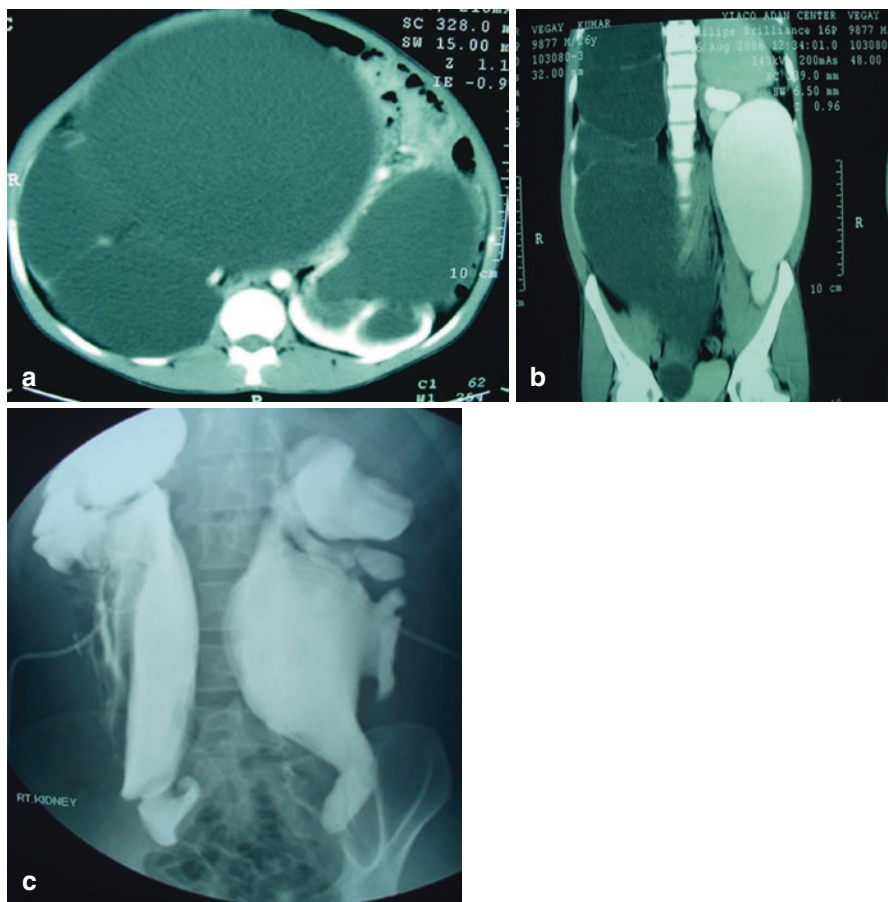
(a) CT with IV contrast showing bilateral giant hydronephrosis occupying the whole abdomen and displacing abdominal contents. (b, c) Antegrade pyelography showing arrest of the contrast at the pelviureteric junction (PUJ). Note the difference in the volume after insertion of the percutaneous nephrostomy (PCN). Right-sided nephrectomy was performed on the poorly functioning right kidney
